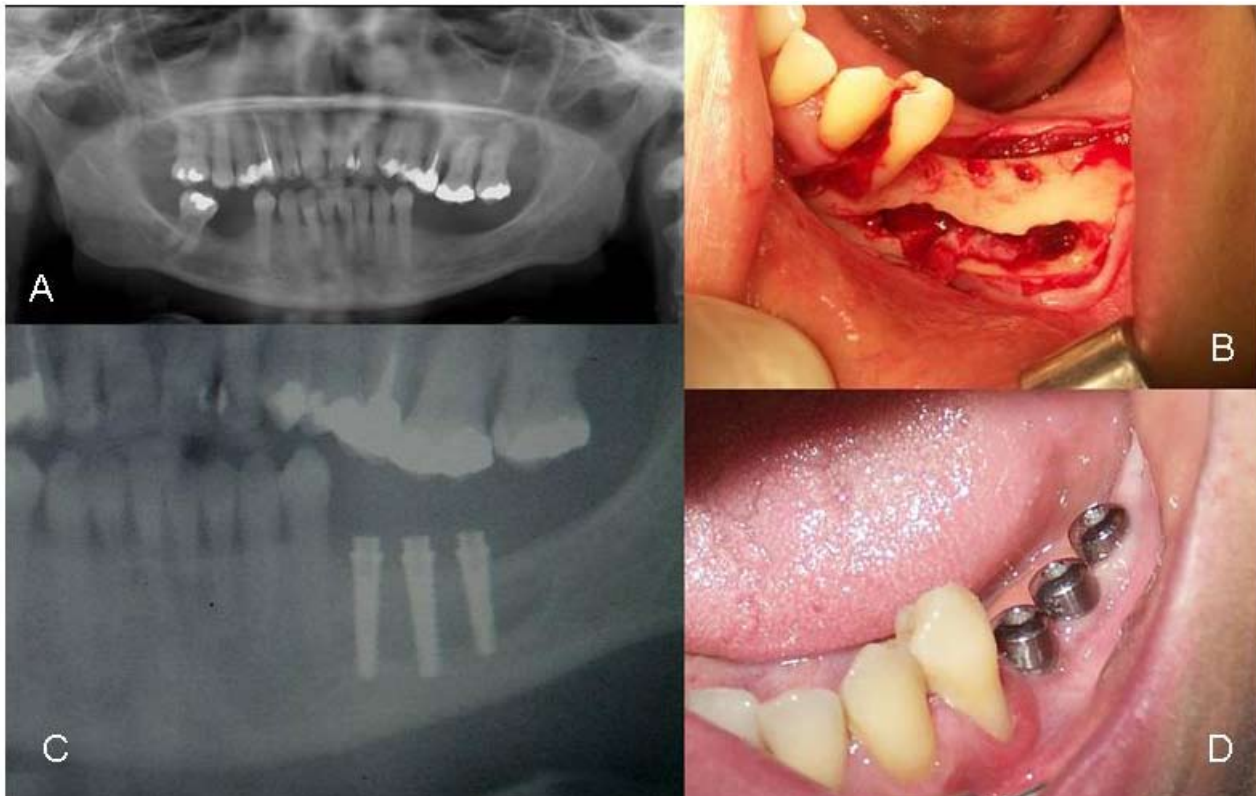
A. Panoramic X-ray view prior to surgery, showing the poor crest height in the mandibular posterior sectors.
